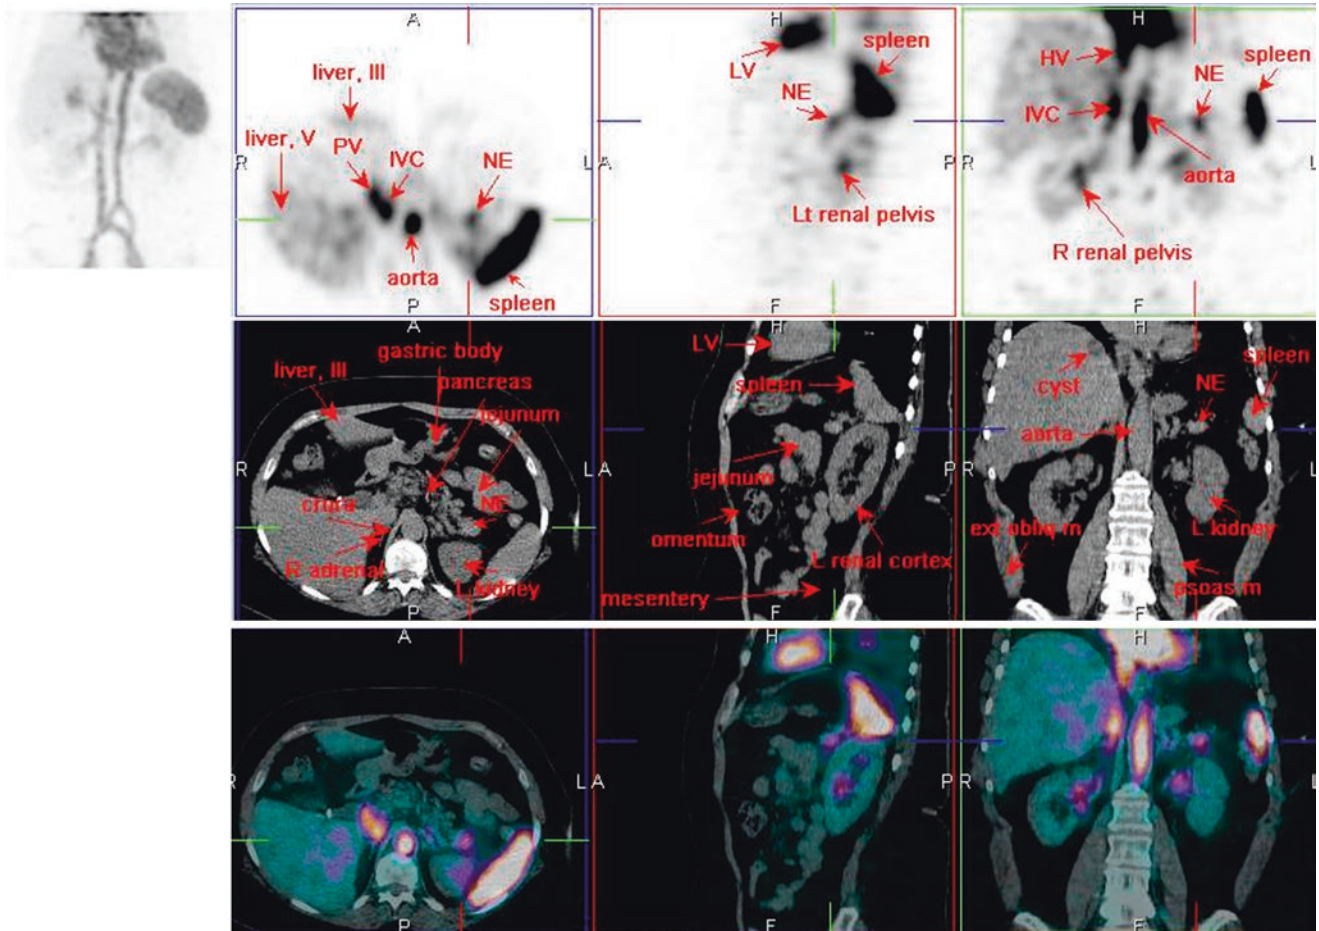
¹¹¹In-octreotide SPECT/CT
